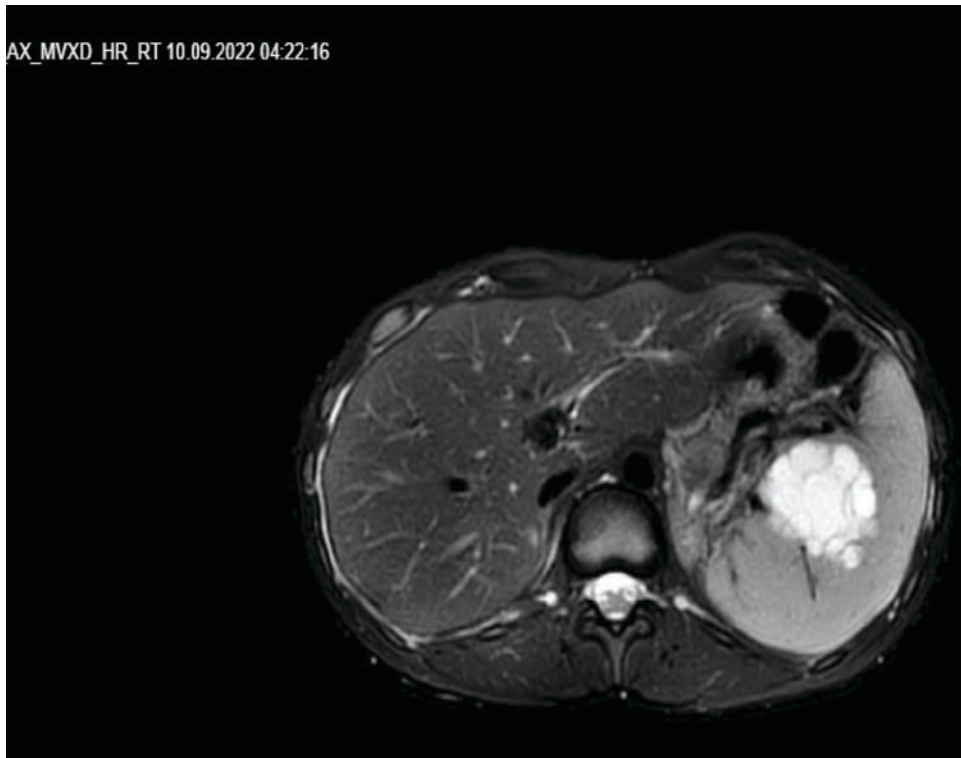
MRI image of the patient's abdomen
